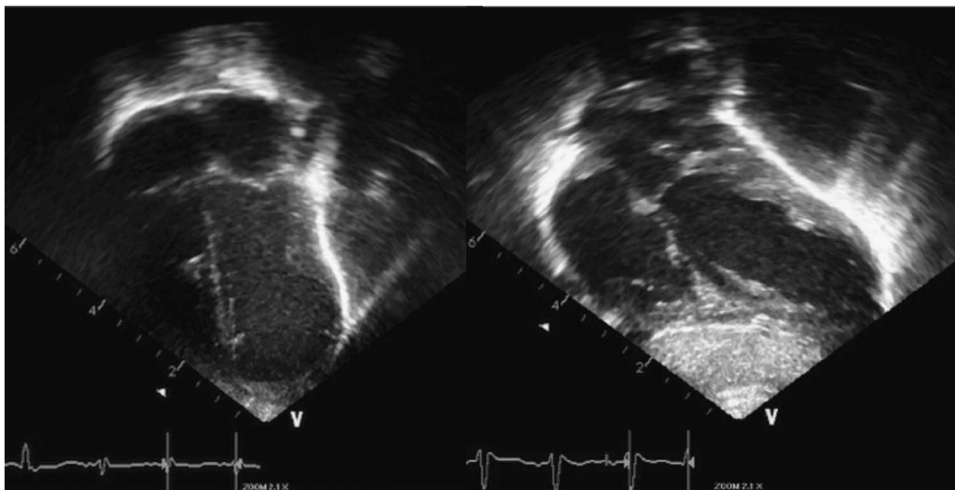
Echocardiogram showing a moderately dilated left ventricle and aneurysmal wall.
